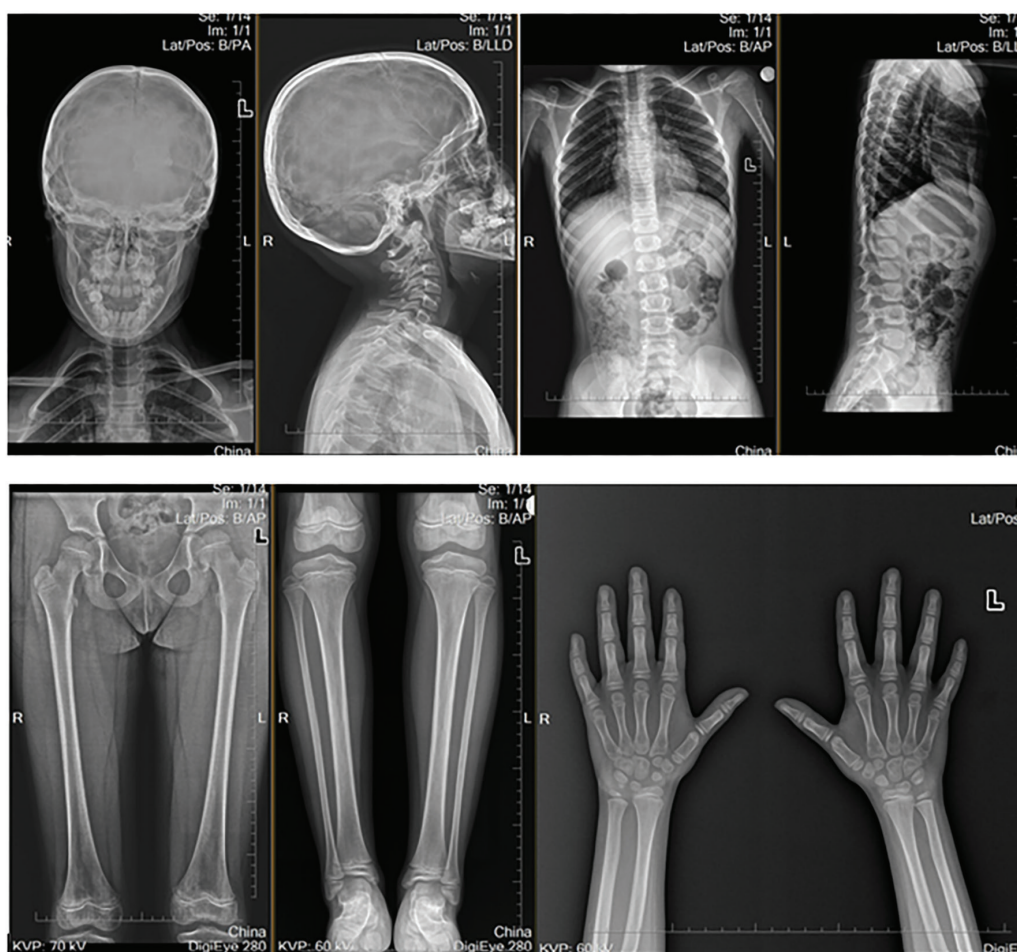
The radiographic bone survey of the patient
